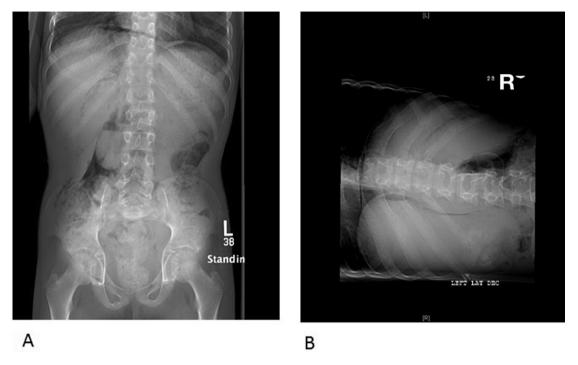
Abdominal X-rays: A: Standing position, B: Left lateral decubitus position.
